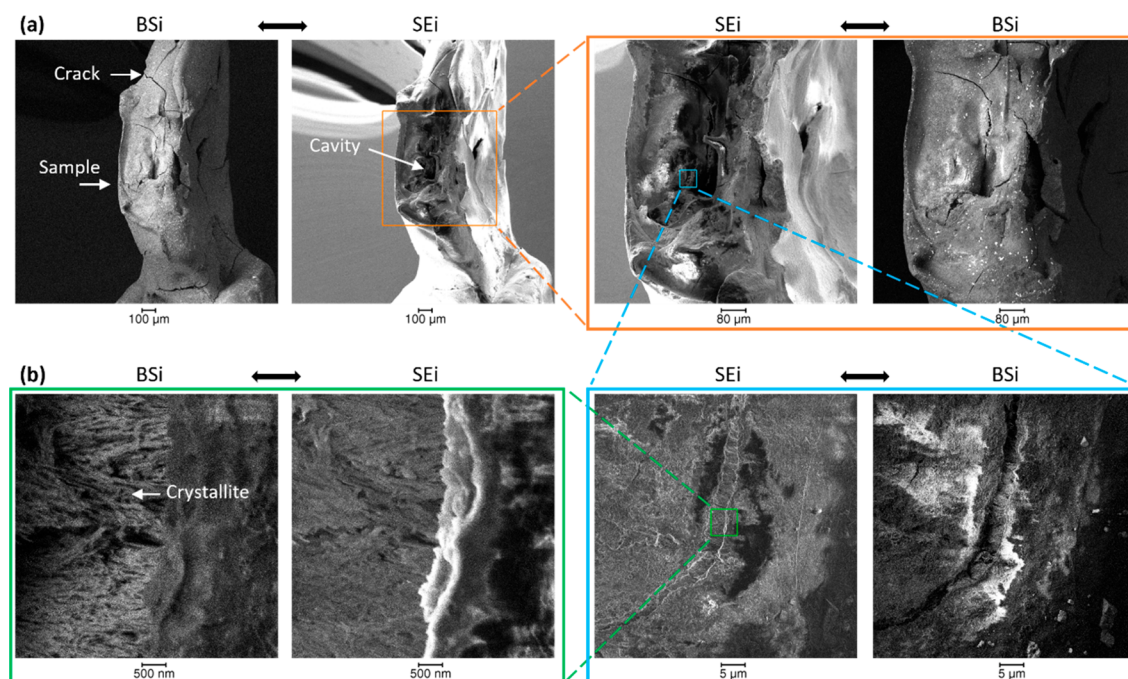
SEM images of the sample after X-ray tomography. (a) SEi and BSi analysis at various magnifications of the enamel showing the demineralized region and overall damages on the sample and (b) high-magnification image.
